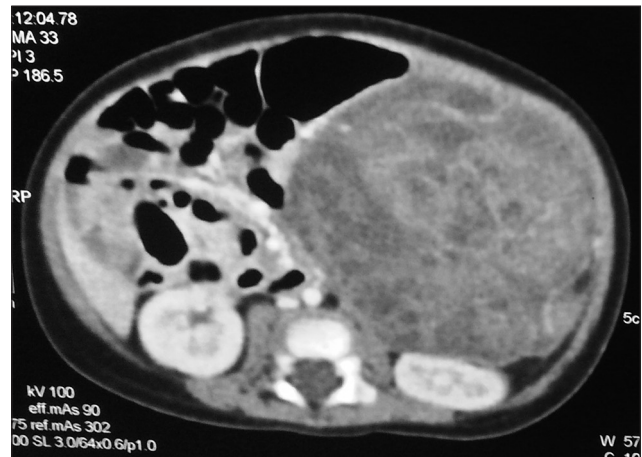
Axial contrast enhanced computed tomography of abdomen showing a large heterogeneous mass pushing the left kidney inferiorly and displacing the gut, no evidence of calcification
